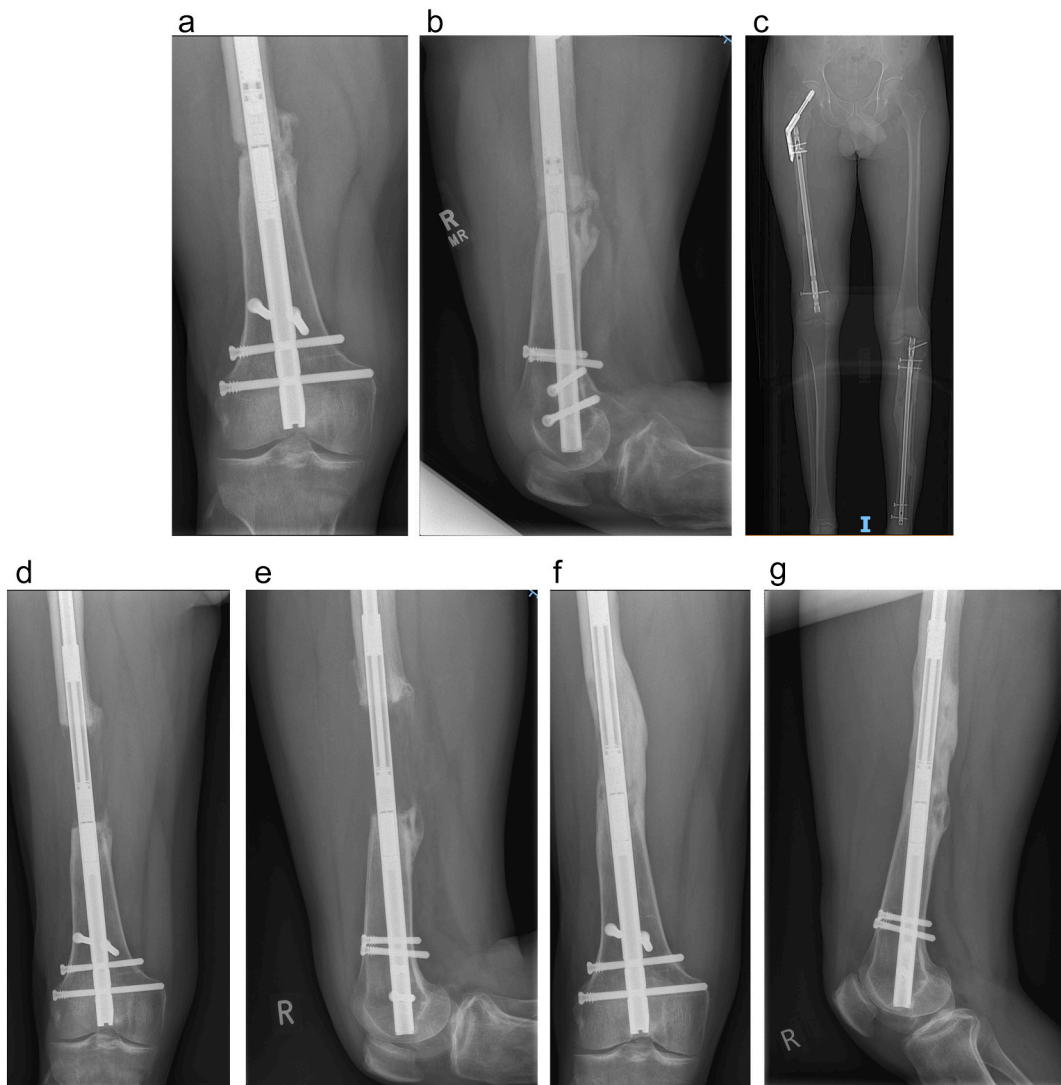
a: AP X-ray of broken distal locking screws, non-union with limited callus formation.
